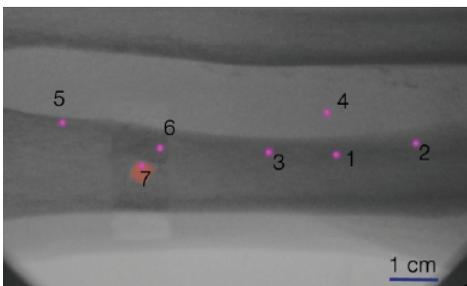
Without X-Grid, 7 fluoroscopic X-rays were needed in order to localize the surgical site on the tibia.
